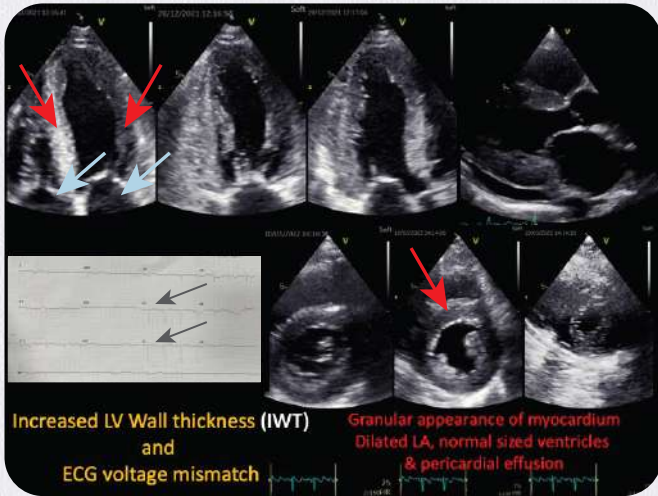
Echocardiographic images are seen with the top row (apical - 4, 2 and 3 chamber views) and bottom row (parasternal short axis views at- mitral valve, papillary muscles and apical levels) showing severe left ventricular hypertrophy due to myocardial amyloid infiltration (red arrows)
